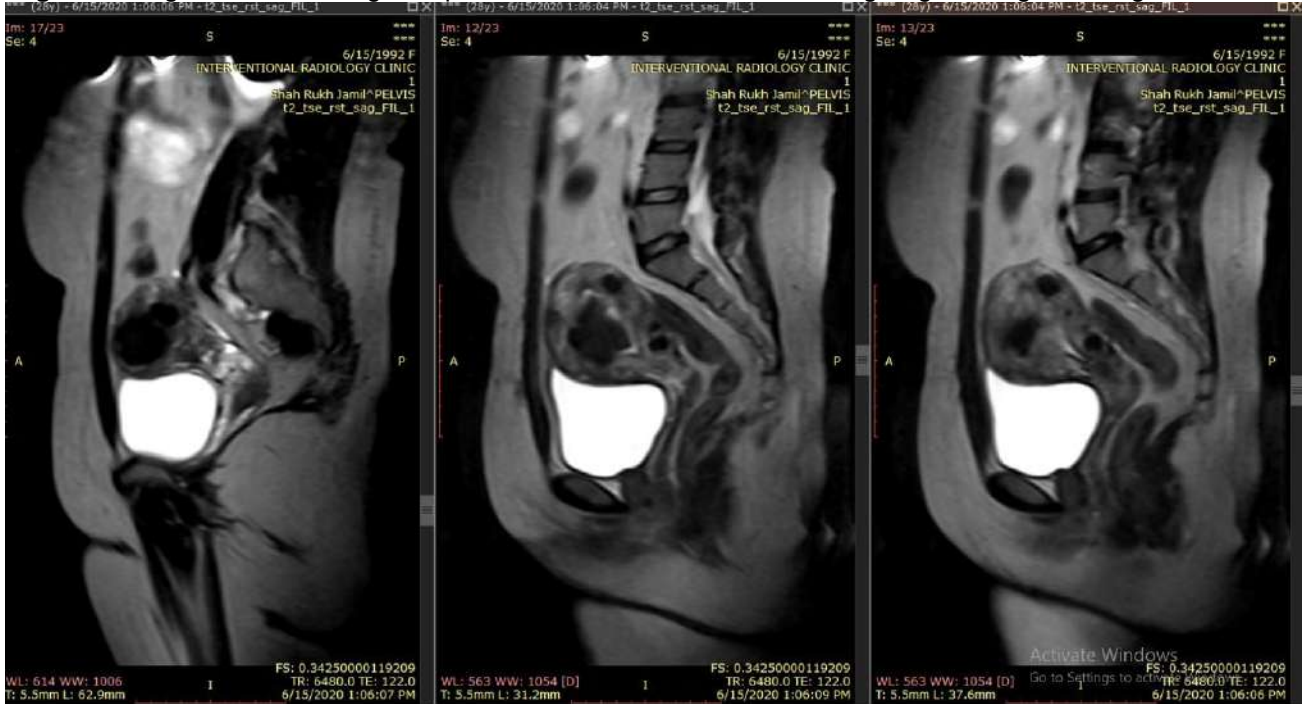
b: T 2 sagittal MRI 3 months after embolization shows complete necrosis of all fibroids which are replaced fluid filled cavities.
